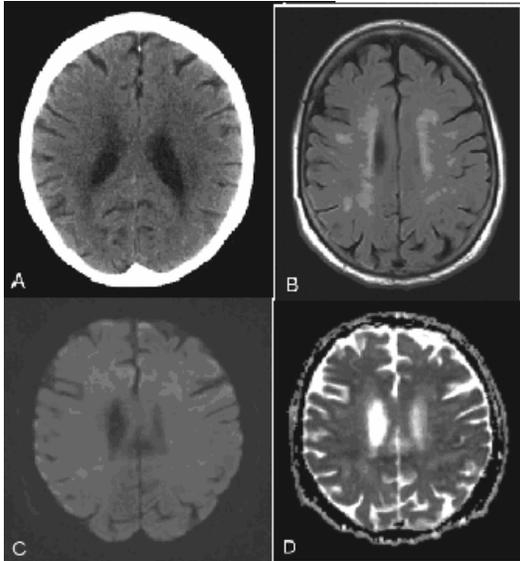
(A–D): 75 year old women admitted > 6 hours after the onset of numbness, paraesthesia and weakness of the left arm. CT (A) was normal. 2.5 days after the onset of symptoms MRI was performed because of persistent paraesthesia of the left arm and fluctuating weakness of the left arm and leg. Large number of UBOs was identified in the white matter on FLAIR (B) but no changes in signal intensity on DWI (C) or ADC-value (D) suggestive of acute/subacute ischemia. Diagnosis at discharge was transient ischemic attack (TIA). Carotid artery doppler ultrasonography showed stenosis of right internal carotis artery.
